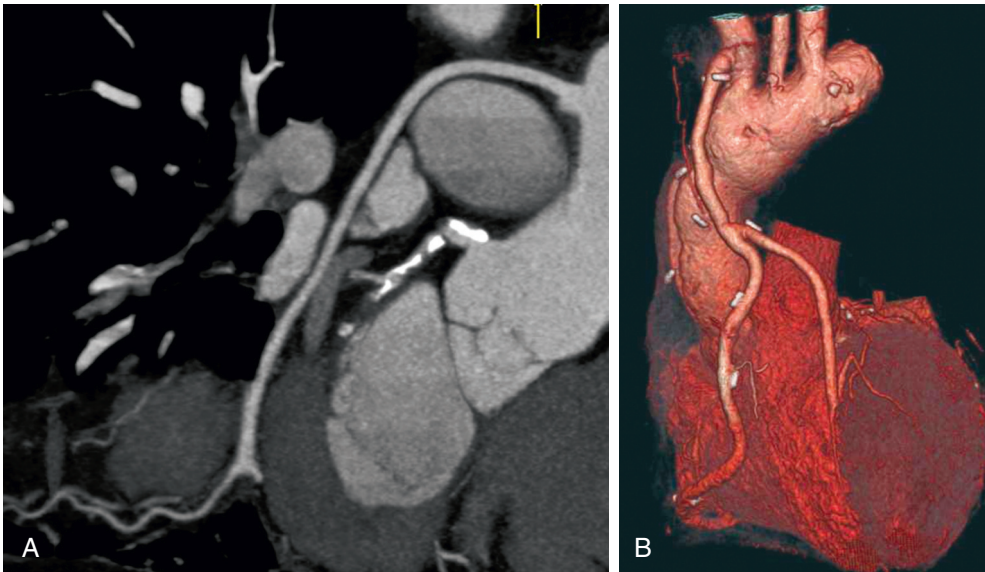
Cardiac CT provides high accuracy for evaluation of coronary bypass grafts owing to their large size, often limited extent of calcified atherosclerosis, and limited mobility, as shown in the oblique multiplanar reformat (A) and three-dimensional volume-rendered reformat (B). (Images courtesy Dr. Stephan Achenbach, Erlangen, Germany.)
